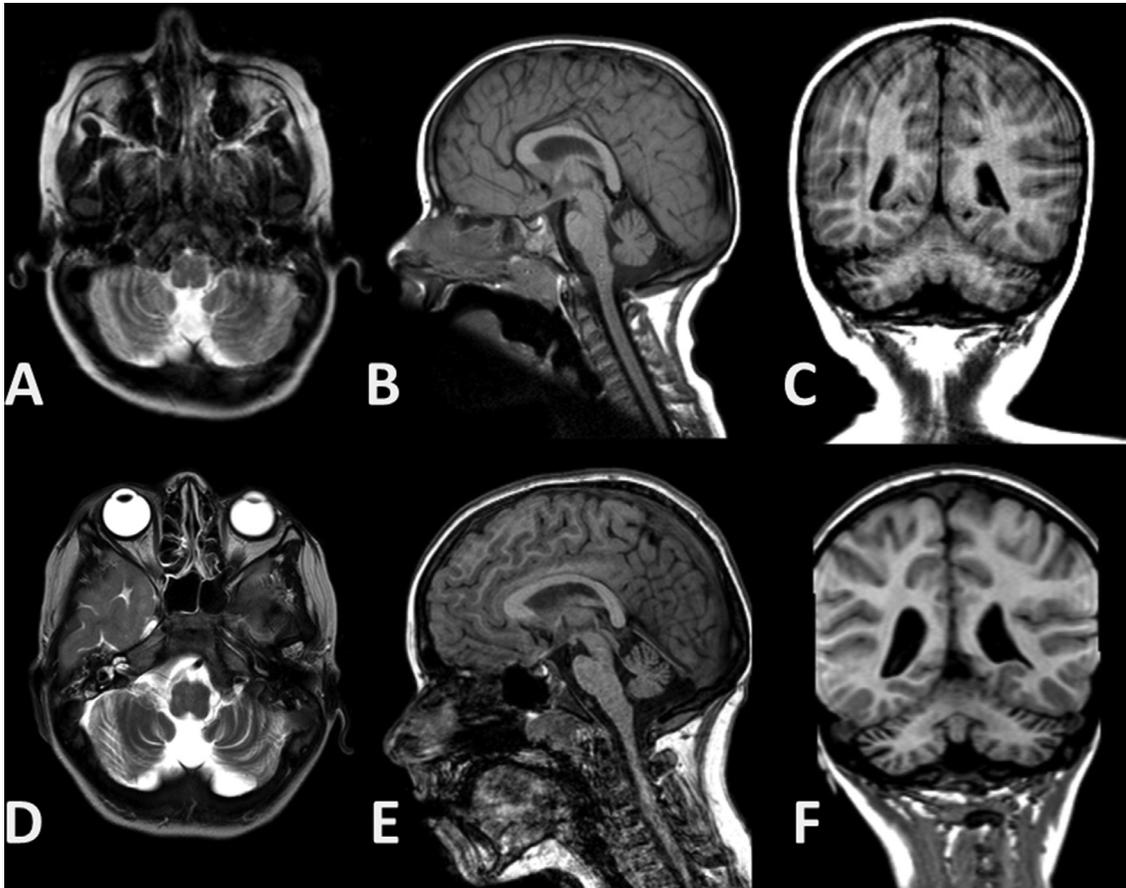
Brain MRI findings in *MSTO1*-RD. Brain MRI images obtained at 5 (A–C) and 12 (D–F) years of age, axial (A,D), sagittal (B,E) and coronal (C,F) sections. There is cerebellar atrophy with evidence of mild progression between the two scans.
